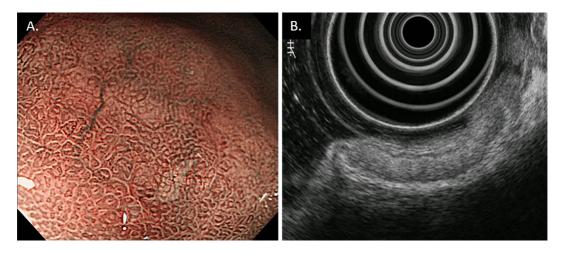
Endoscopic images of LGA at 10 years after the initial examination. Magnifying endoscopy with narrow-band imaging showed a dilated vessel but neither microvessel nor microsurface irregularity (A). In EUS, the lesion in the third layer consisted of a relatively uniform hyperechoic finding in the superficial part and gradual hypoechoic findings in the deeper part (B). LGA: localized gastric amyloidosis, EUS: endoscopic ultrasonography
